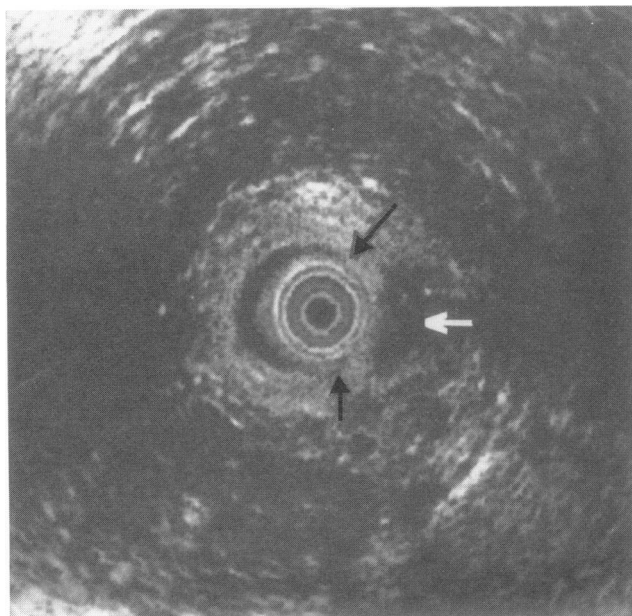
Combined anterior external (white arrow) and internal (black arrows) sphincter defects seen at endosonography. The orientation of the image is as seen when scanning in the left lateral position.
